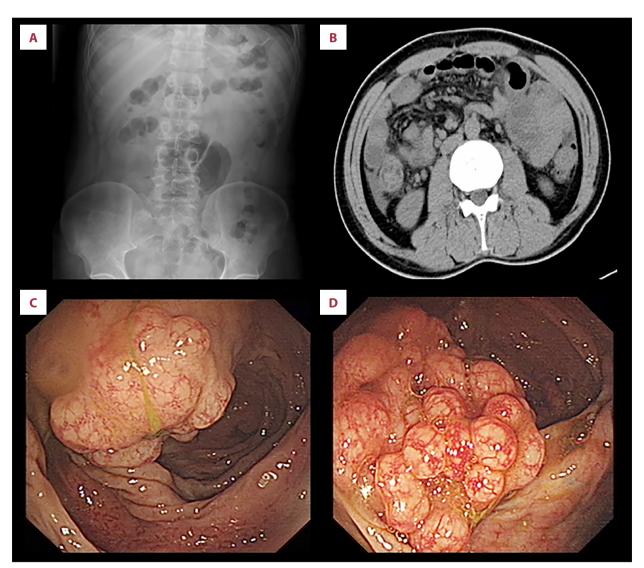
Intussusception resulting from multiple lymphomatous polyposis due to mantle cell lymphoma. (A) Plain abdominal radiograph shows a nonspecific air pattern. (B) Computed tomography (CT) scan shows ileocecal intussusception, thickening of the bowl wall, and enlargement of the mesenteric lymph nodes. (C, D) Colonoscopy shows polypoid lesions of the large bowel, consistent with multiple lymphomatous polyposis.
